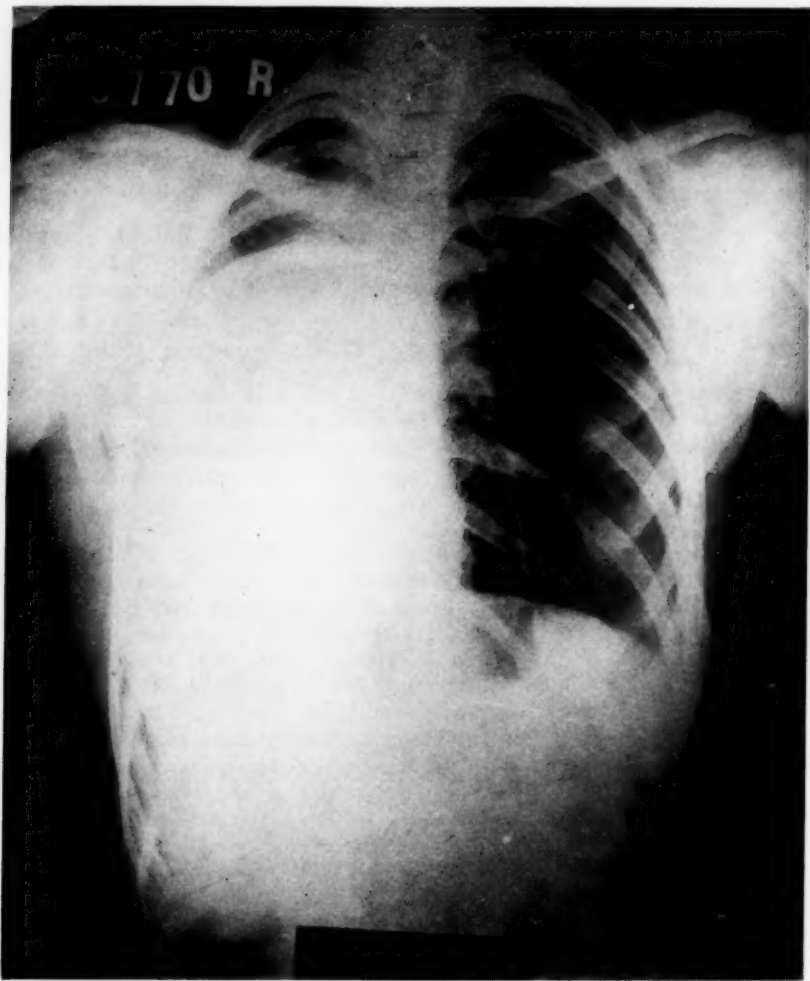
Roentgen-ray, March 16, showing lower two-thirds of the right lung obscured by dense shadow and heart and mediastinum drawn to the right.
